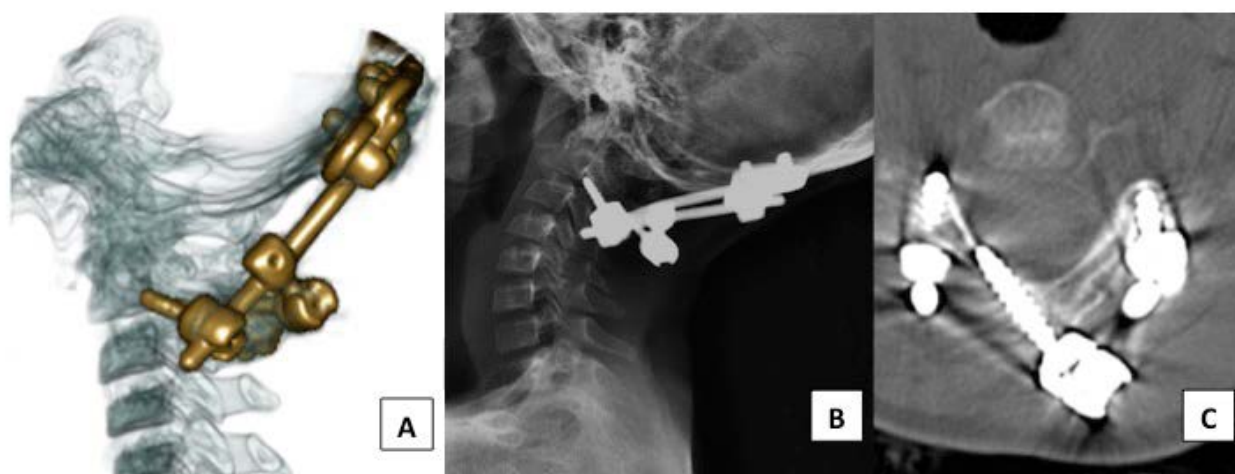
An occipitocervical fusion for treatment of a bone cyst of the atlas. (A) Sagittal CT scan reconstruction, (B) postoperative lateral extension cervical spine X-ray and (C) axial CT scan showing a right C2 laminar screw and bilateral C2 pars screws.
